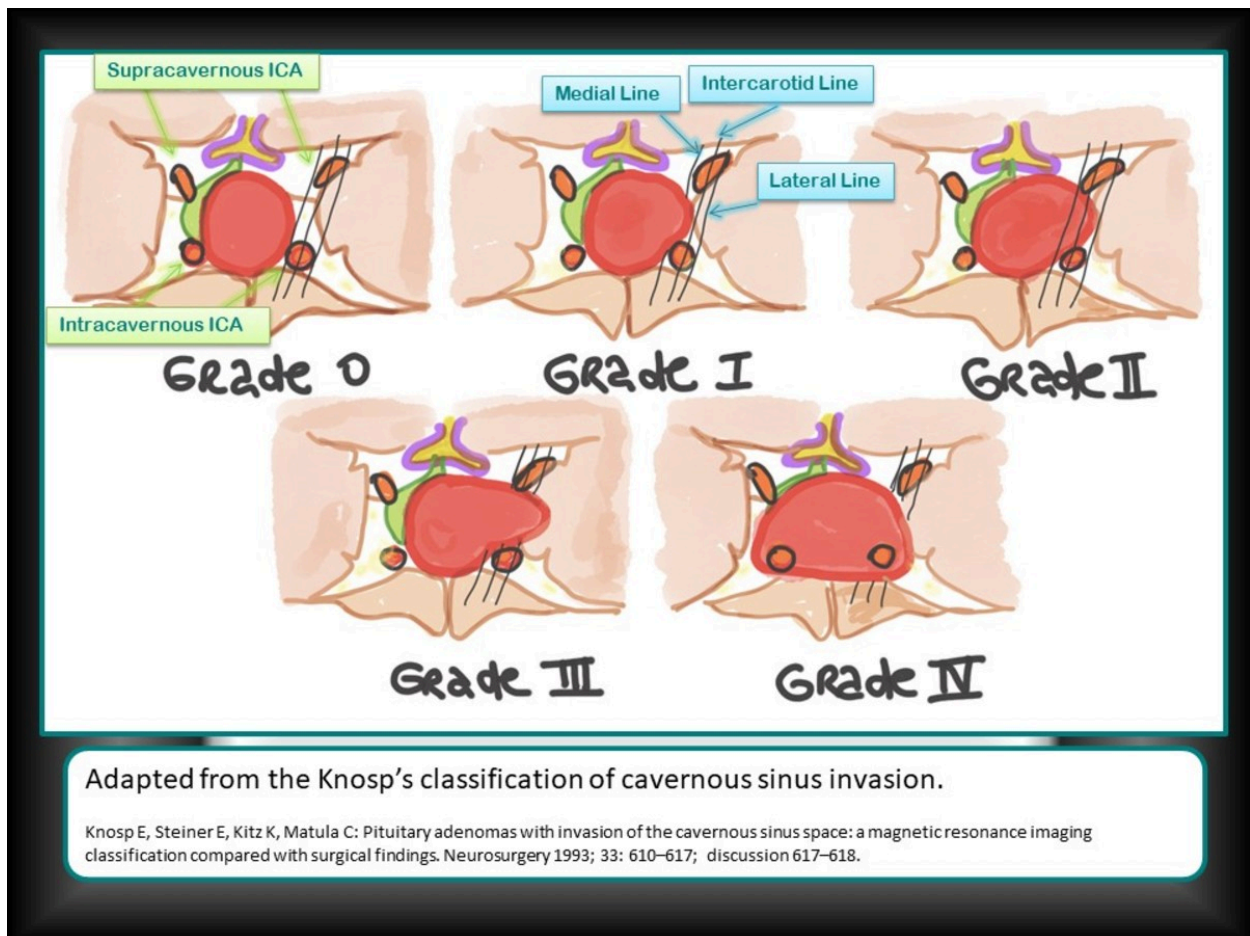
ADAPTED FROM THE KNOSP'S CLASSIFICATION OF CAVERNOUS SINUS INVASION. Knosp et al. offered a grading system for predicting invasion of the cavernous sinus by pituitary macroadenoma on the basis of MRI. This represents the parasellar extension of the tumor. Reference: Knosp E, Steiner E, Kitz K, Matula C: Pituitary adenomas with invasion of the cavernous sinus space: a magnetic resonance imaging classification compared with surgical findings. *Neurosurgery* 1993; 33: 610-617; discussion 617-618.
